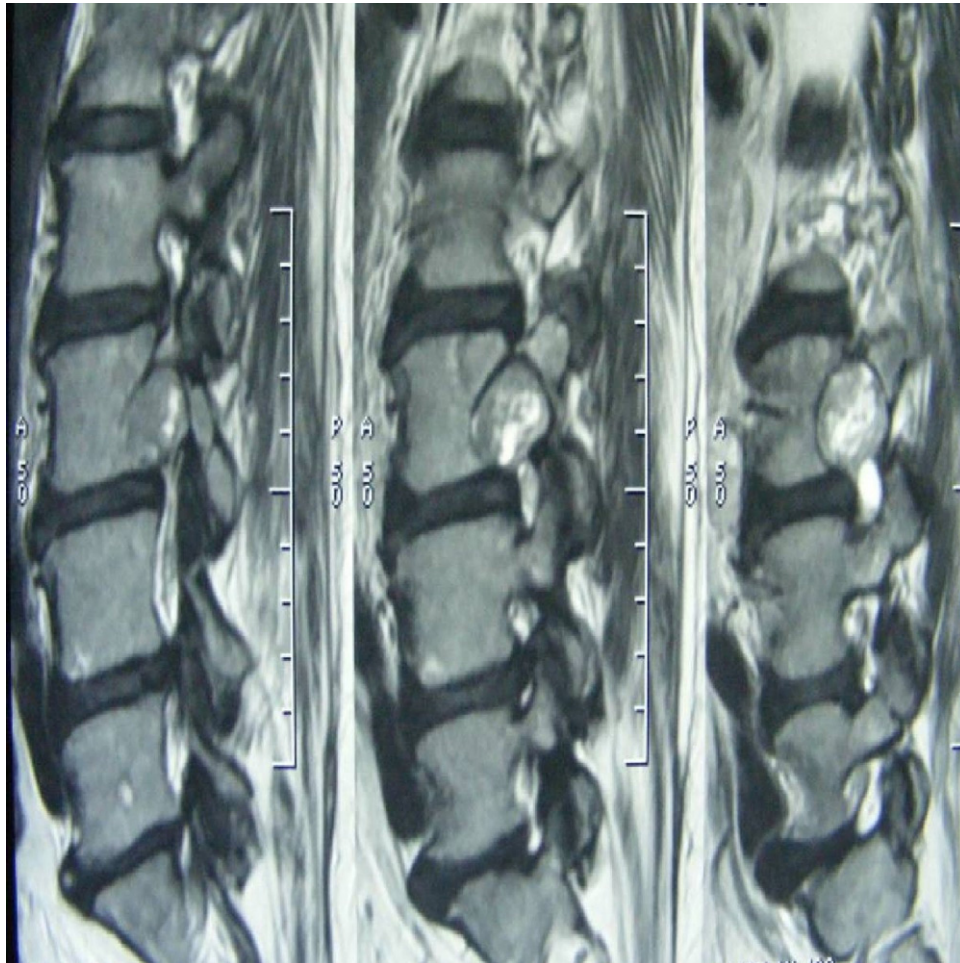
T1-weighted MRI sagittal section of the lumbar spine shows the tumor exiting the foramen.
